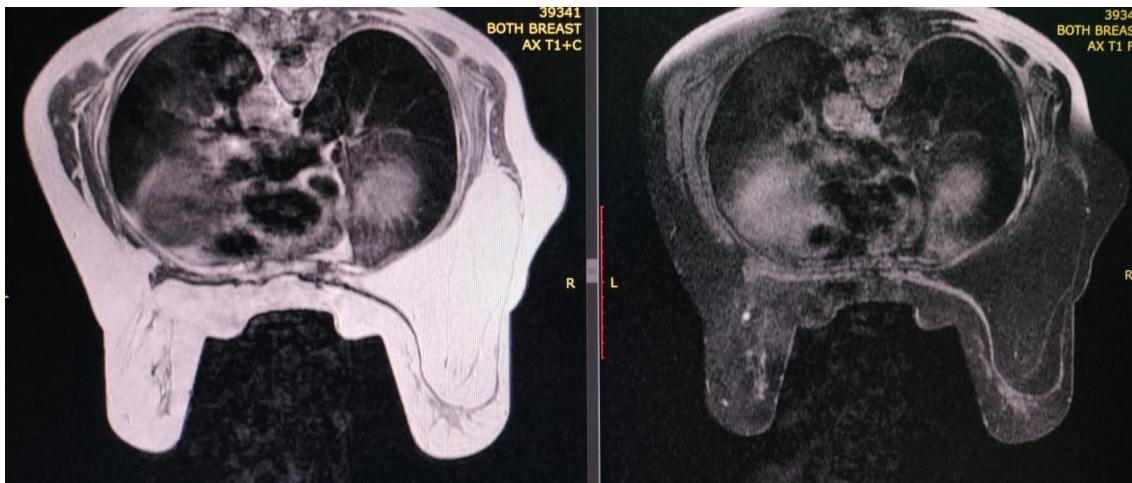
MRI breast showing right giant subpectoral lipoma.
